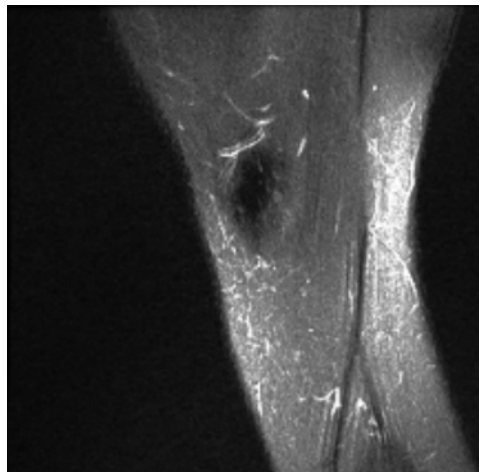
Example of MRI cut in absence of features information. *Source: MRNet. [33]*
